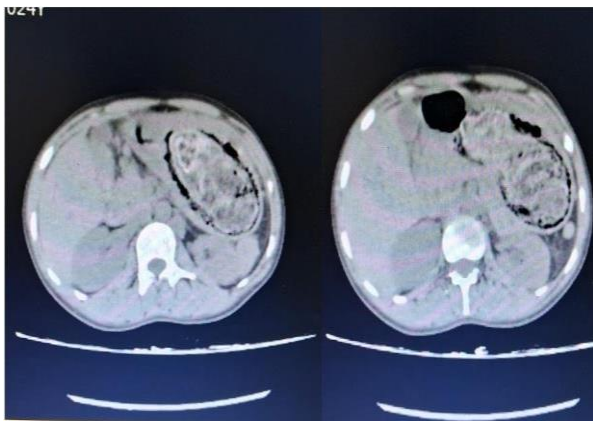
CT Abdomen Showing Gastric Intraluminal Trichobezoar
